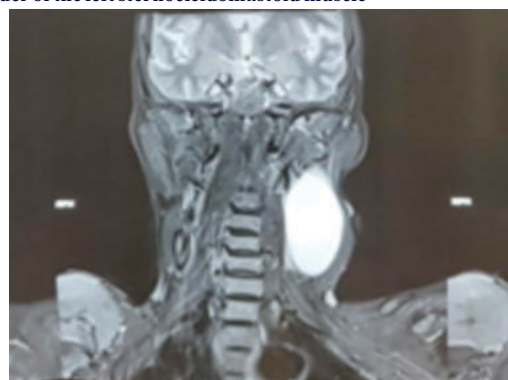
MRI image showing the mass lesion abutting the internal jugular vein, localized swelling with no local infiltration
